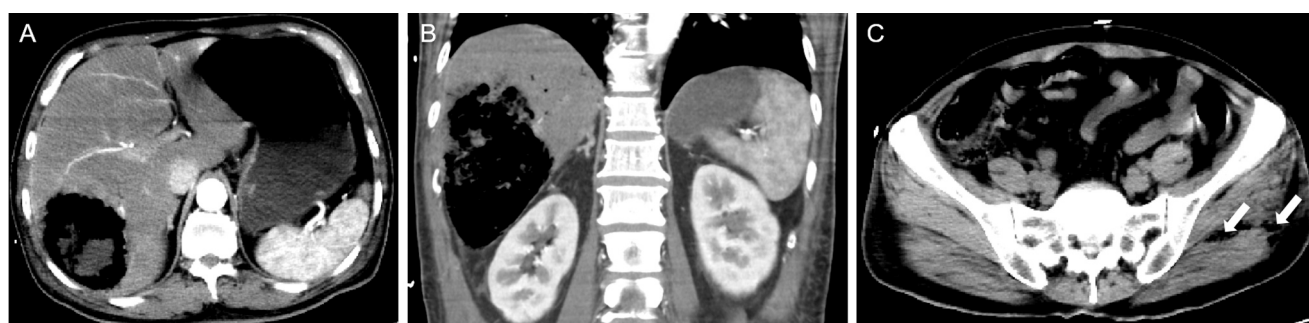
Abdominal CT. A and B: Axial (A) and coronal (B) computed tomography scans of emphysematous hepatitis, showing an 86 mm by 65 mm area of gas in the right hepatic lobe. C: Axial (A) computed tomography scans of hypogastrium, showing a multitude of air bubbles beneath the skin and within the muscular structure of the left gluteal region.
